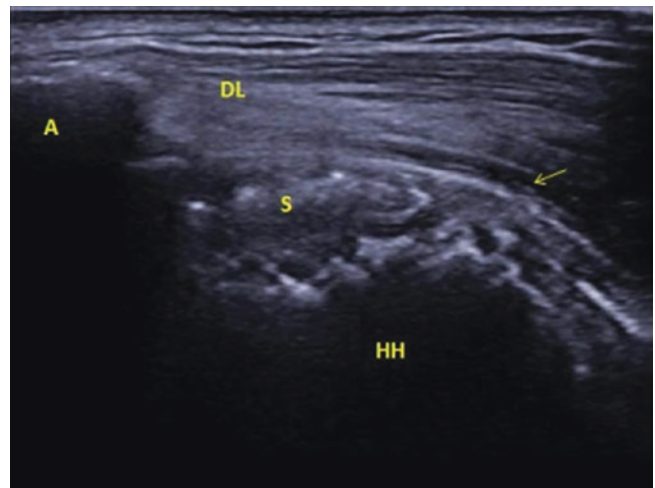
If fluid is present within the bursa, it can be aspirated. This image shows the same patient as Fig. 2.11 after aspiration of the subacromial bursa fluid. The acromion (A) is to the left, with the deltoid (DL) on top of the bursa and the supraspinatus tendon (S) below. The *arrow* indicates the subacromial bursa. The humeral head (HH) is deep to the overlying structures. Video 2.2 shows dynamic ultrasound imaging used to assess for subacromial impingement of the supraspinatus tendon
